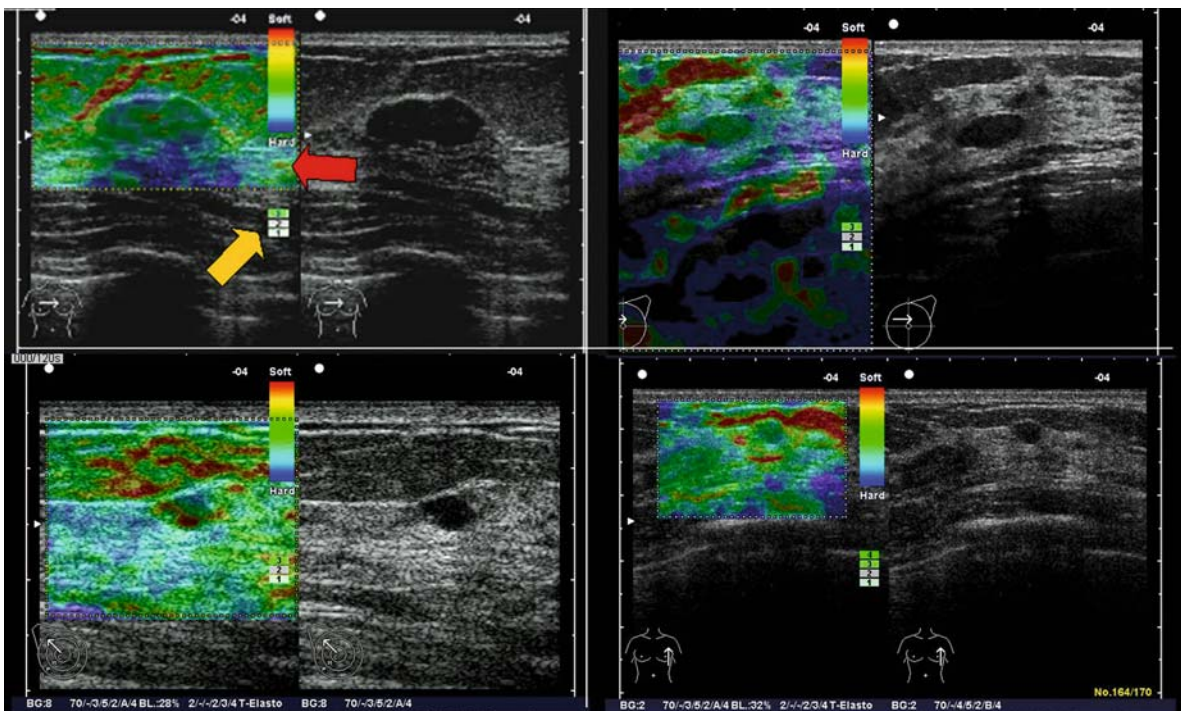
Small nodes presenting as benign at elastosonography (cytological confirmation)
